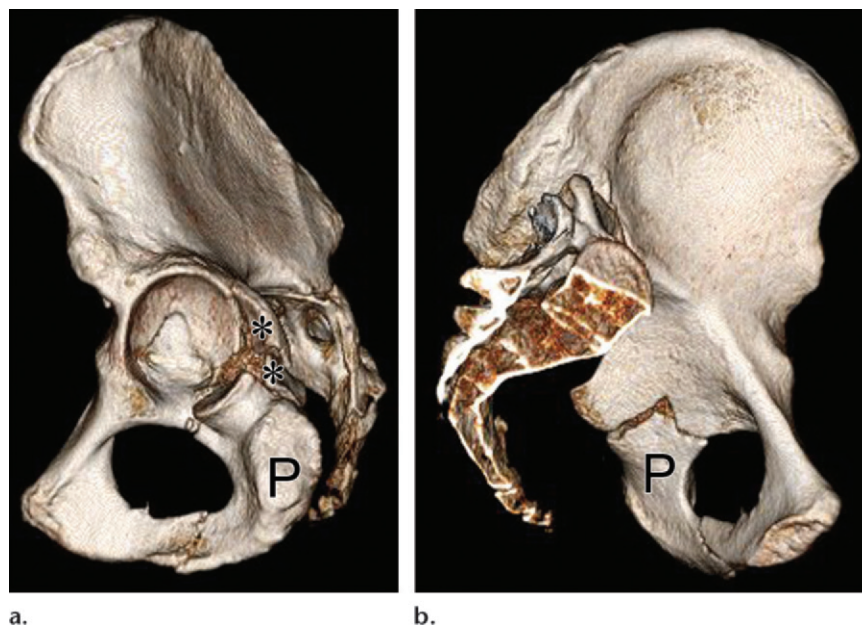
Anterior column or wall with posterior hemitransverse acetabular fracture in two patients. (a, b) Lateral (a) and medial (b) 3D surface-rendered CT images show that the anterior component of the acetabulum (*) is separated from the sciatic buttress and contains a large portion of the anterior column, making this an anterior column with posterior hemitransverse fracture. The posterior hemitransverse component (arrow) is seen on both medial and lateral views. (c, d) Lateral (c) and medial (d) 3D surface-rendered CT images obtained in a different patient show a mildly displaced anterior wall with posterior hemitransverse acetabular fracture. The anterior component (*) is separated from the sciatic buttress and contains the anterior articular surface and the portion of the anterior column just anterior to the acetabular cup. The posterior hemitransverse component (arrow) is seen on both medial and lateral images. (Fig 15c and 15d courtesy of David Lawrence, MD, University of Virginia.)
